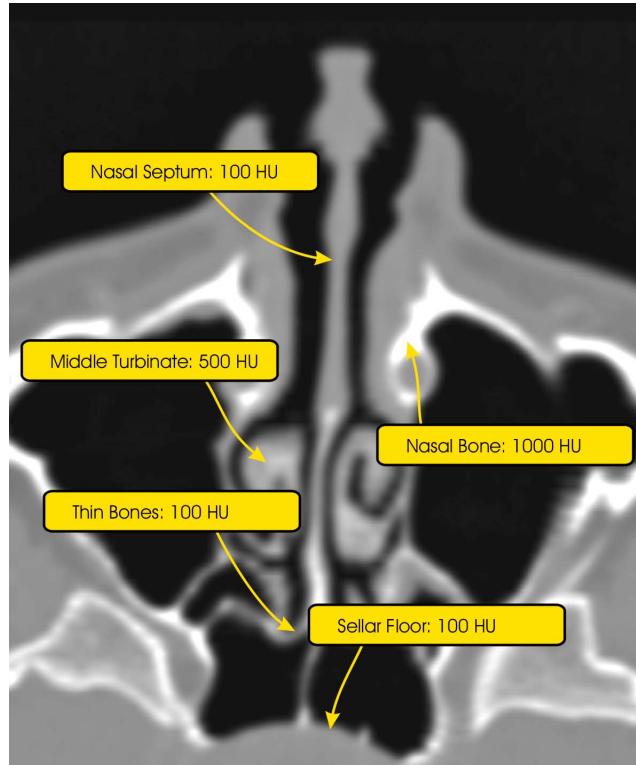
The CT values of bony structures vary significantly: Bones encasing the sphenoid sinus are measured at the same or even a smaller data level than, for example, the outer, cartilaginous part of the nasal septum.
